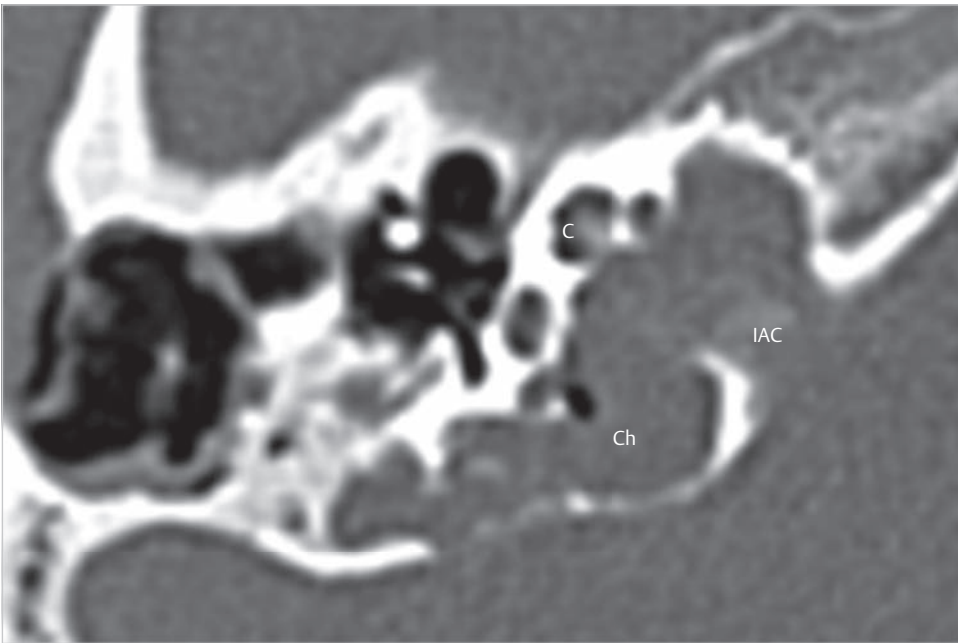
The preoperative axial CT demonstrated that the cholesteatoma has advanced far medially from the partially opened mastoid, eroding the posterior labyrinth, the cochlea, and the internal auditory canal to reach the petrous apex. C, cochlea; Ch, cholesteatoma; IAC, internal auditory canal.
